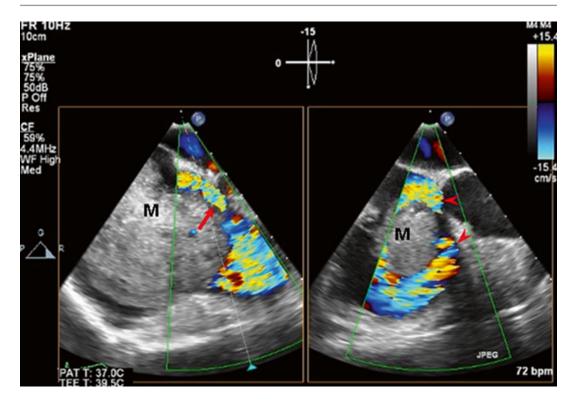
2D TEE color Doppler, x-plane view, showed moderate TR (*arrows*) due to incomplete TV closure 📀
